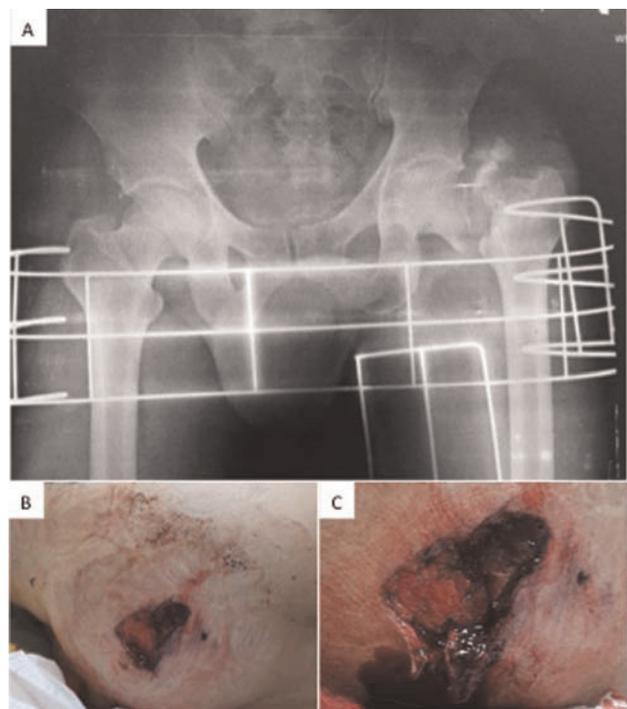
Clinical and radiographic evaluation in the initial care provided to the patient: (A) panoramic anteroposterior radiograph of the pelvis showing a comminuted fracture at the left femoral neck with significant cephalic migration; (B) wound at the left gluteal region; (C) extensive muscle injury with bleeding and bone splinters confirming the diagnosis of open femoral neck fracture.
